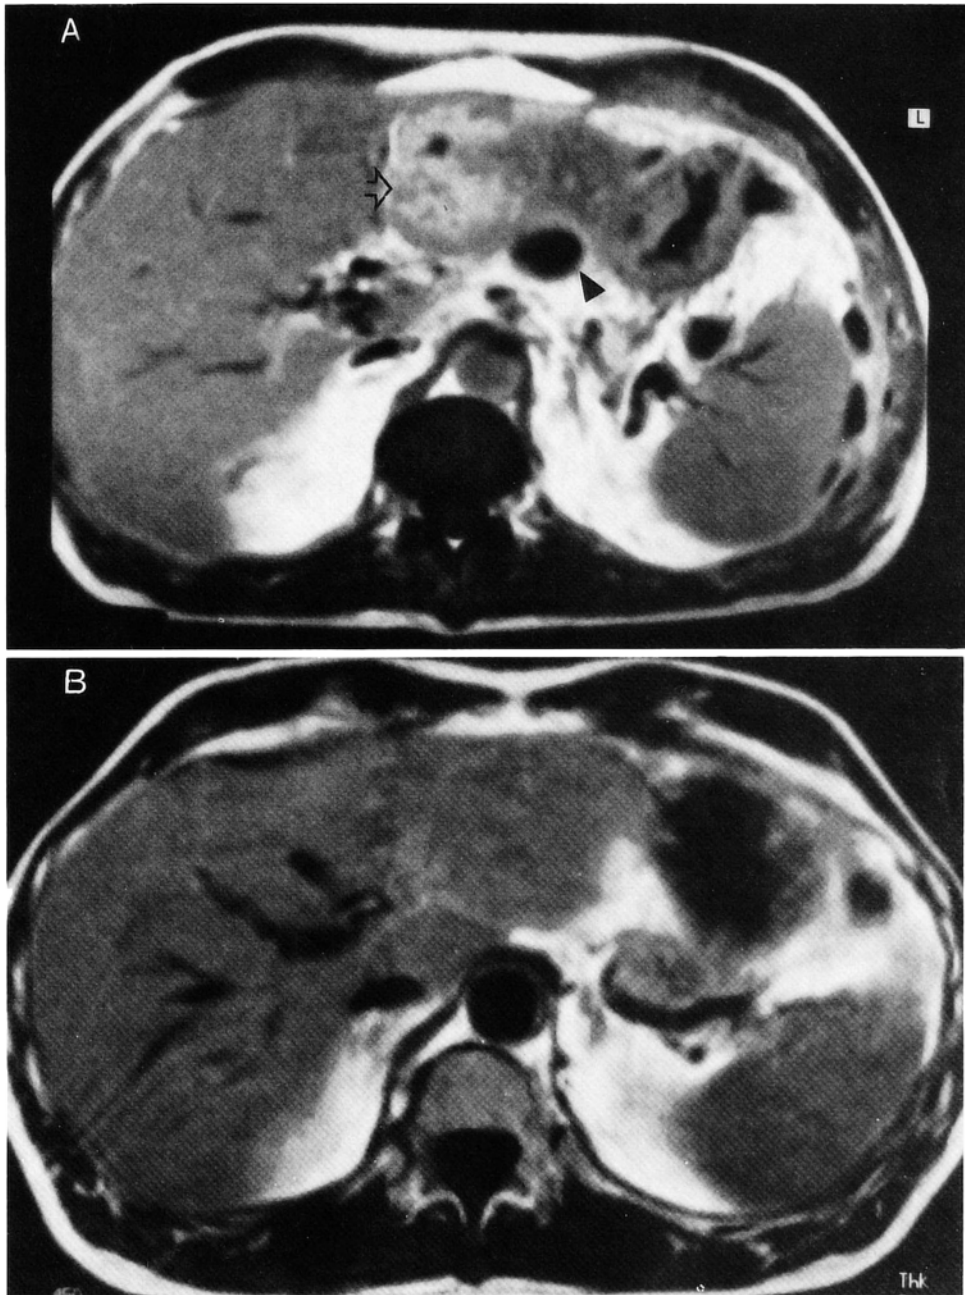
(A) Initial MR imaging (T1 SE weighted sequence after injection) showed a heterogeneous lesion in the left lobe of the liver (white arrow). Hepatic effusion (arrow head). No enhancement of the left portal vein is observed. (B) MR imaging performed two months later showed vanishing of the focal liver lesion.
